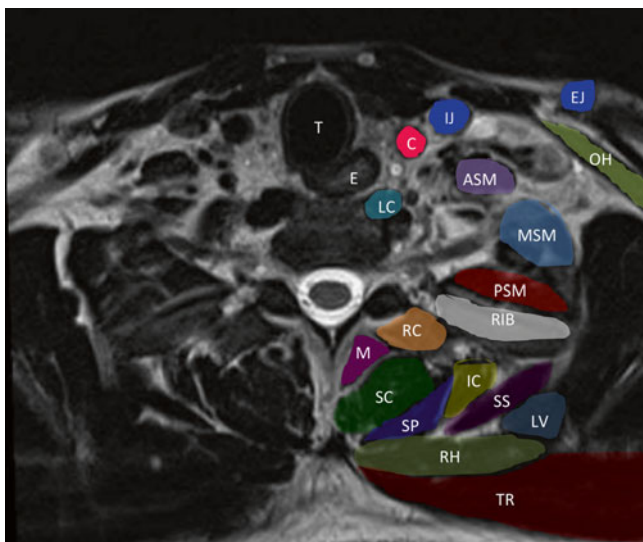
Axial MRI of the lower neck. ASM anterior scalene muscle, C carotid artery, E esophagus, EJ external jugular vein, IC iliocostalis muscle, LC longus coli muscle, LV levator scapula muscle, M multifidus muscle, MSM medial scalene muscle, OH omohyoid muscle, RC rotator cervicis muscle, PSM posterior scalene muscle, RH rhomboid muscle, RIB rib, SC semispinalis cervicis muscle, SP splenius capitis muscle, SS serratus posterior muscle, T trachea, TR trapezius muscle (Image courtesy of Andrea Trescot, MD)
